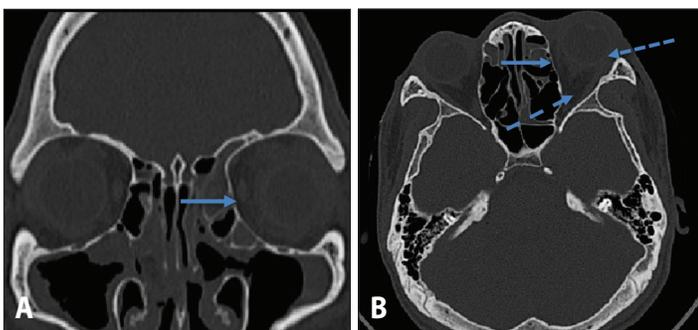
Post-operative CT scans showing intact lamina papyracea (solid arrows); A. coronal view; B. axial view. No hemorrhagic collection is seen in intraconal and extraconal spaces (dashed arrows).
